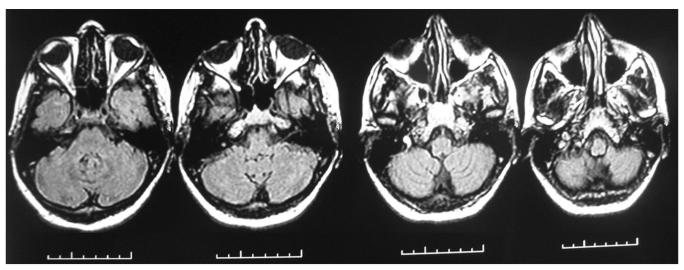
FLAIR-weighted MR imaging shows normal cerebellum
